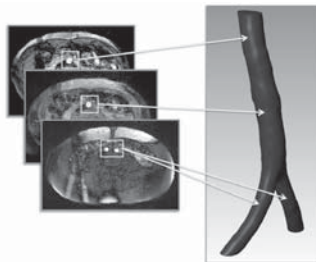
Example of the MRI images used for segmentation of the AA lumen. The example originates from a 28 years old female volunteer.
